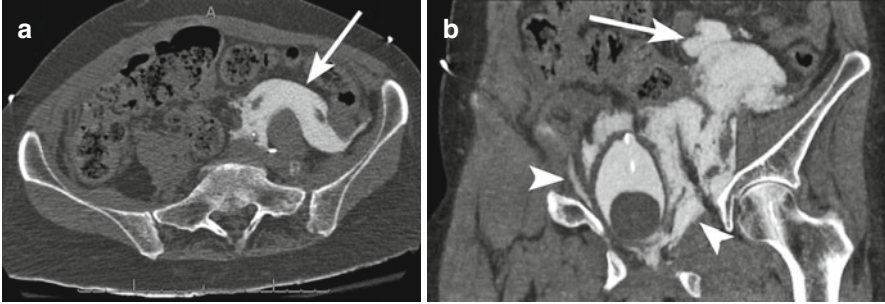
A 66 year-old female presents after motor vehicle collision. Axial (a) and coronal (b) computed tomography (CT) images during CT cystogram show extravasated contrast from the bladder filling the perivesical spaces (*arrowheads*) of the extraperitoneal compartment of the pelvis and extending around small bowel in the inferior peritoneal cavity (*arrow*)
